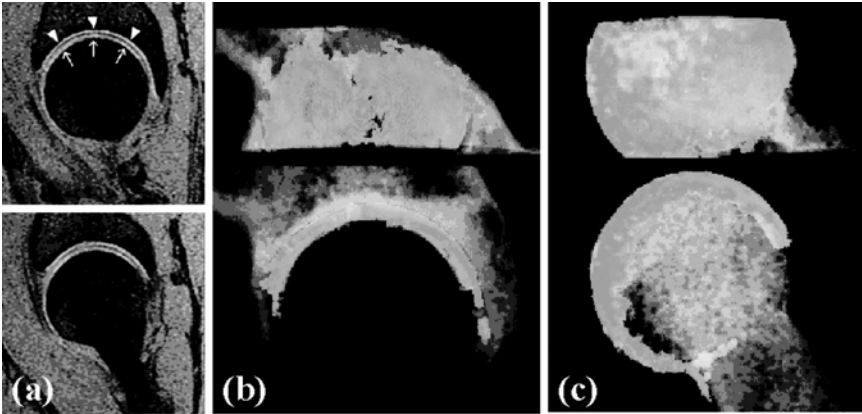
Thickness estimation of cartilages from MR images. (a) Original MR images. The acetabular (pelvic side) cartilages are shown by arrowheads and the femoral head cartilages by arrows. (b) Thickness distribution of acetabular cartilages. The bone regions are volume-rendered in white. (c) Thickness distribution of femoral cartilages. (A color version of this figure will appear on the CD that accompanies the volume.)
